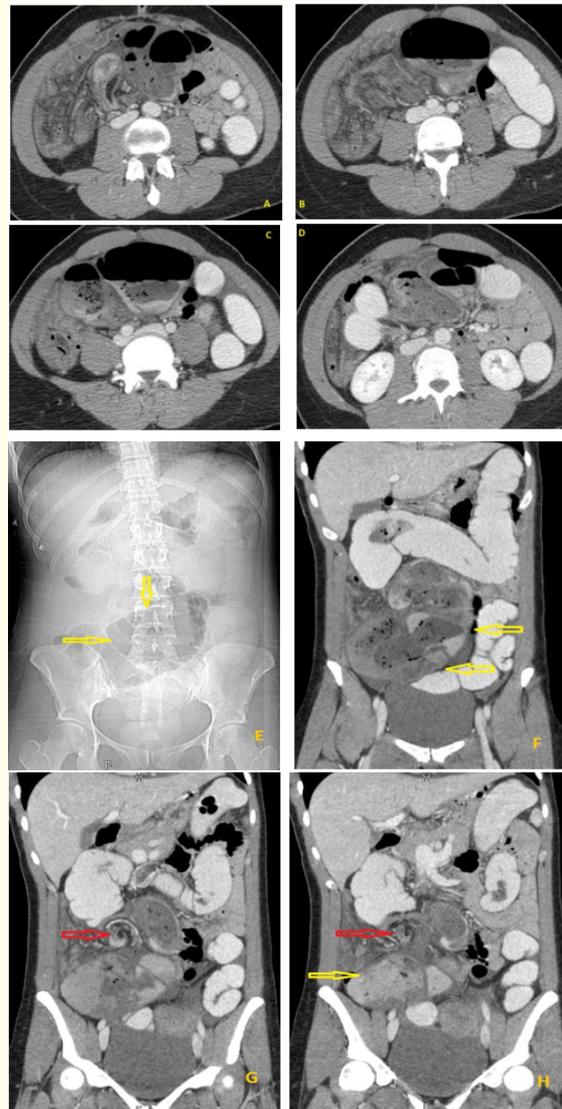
The axial CT scan (A-D), scout view (E), coronal CT (F-H) showing a dilated cecum (yellow arrows), with peaking and swirling of mesenteric vessels (red arrows) at its transition to a collapsed colon.
